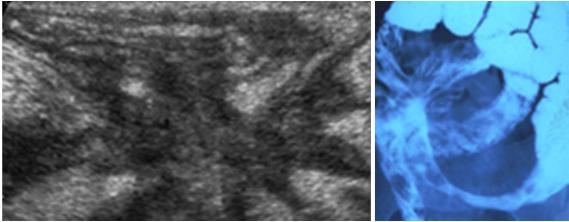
a, b Inter-enteritic fistulas in Crohn's disease; complete sonographic aspect left image half; LAs transverse (a)
